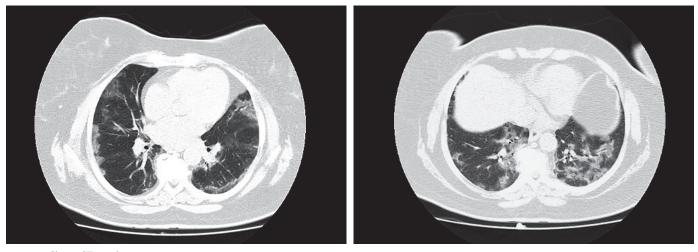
Chest-CT at admission.
